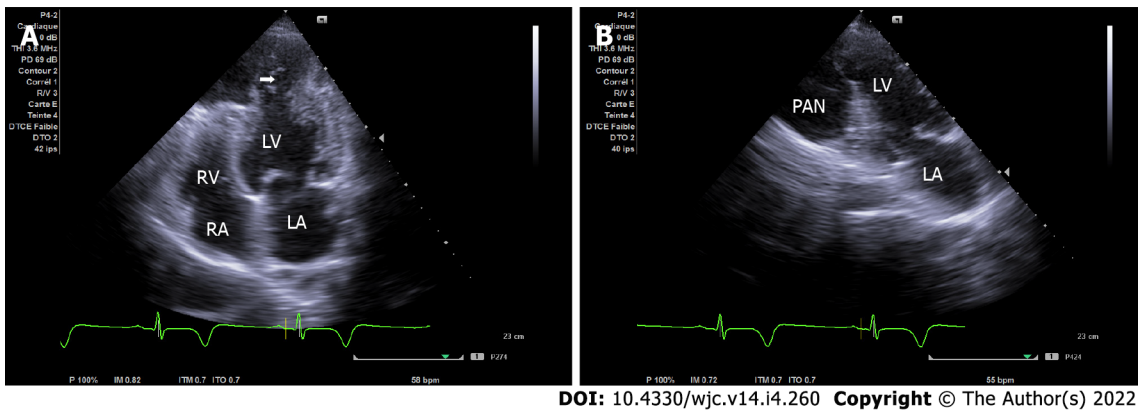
Apical chamber view on transthoracic echocardiogram. A: Apical four-chamber view demonstrating the narrow neck of a pseudoaneurysm (PAN) in the apical wall (arrow indicates the site of free wall rupture); B: Apical two-chamber view demonstrating a second PAN of the infero-apical wall. LA: Left atrium; LV: Left ventricular; RA: Right atrium; RV: Right ventricular.
